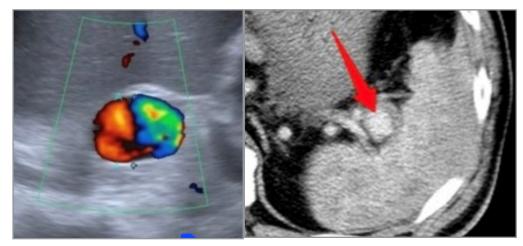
"Korean Flag pattern" (left), CT-angio (right). (From web)
